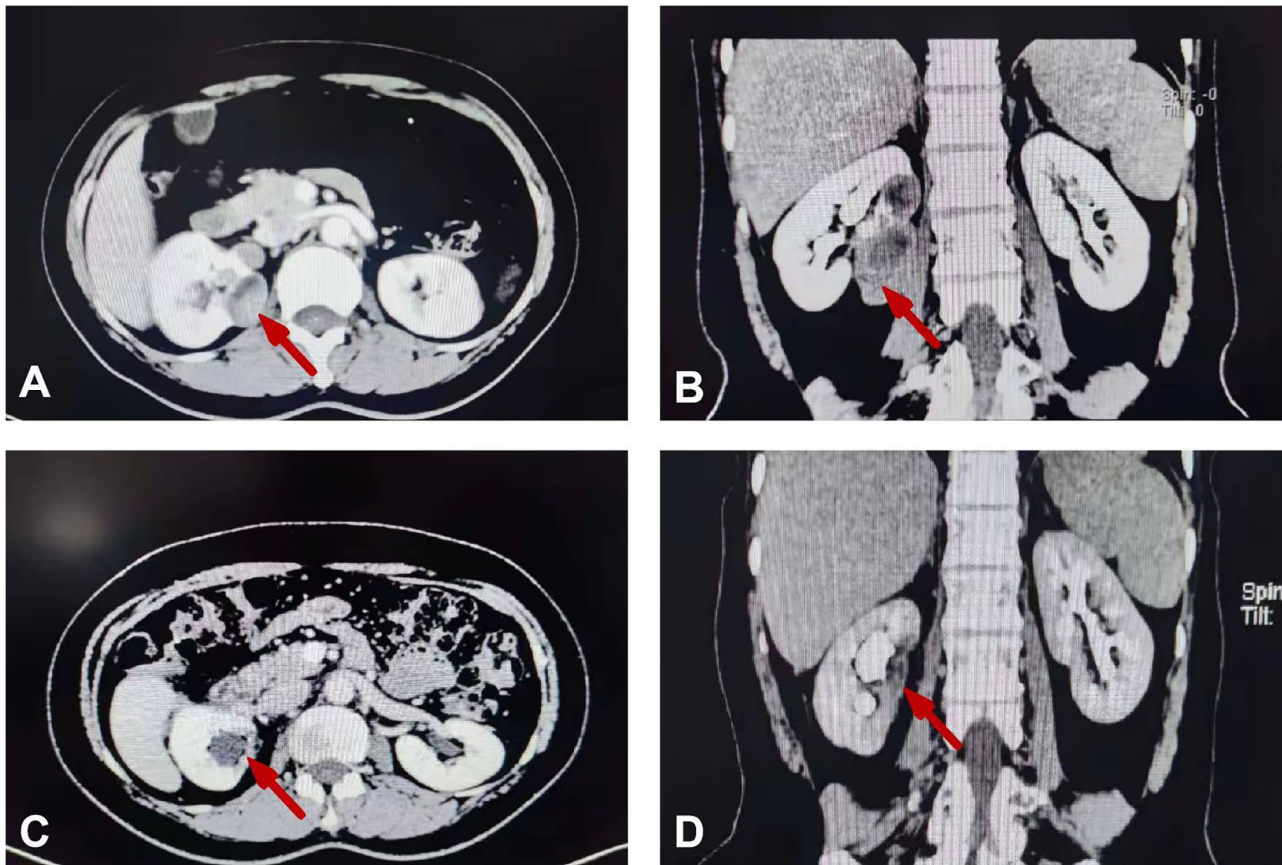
Results of abdominal computed tomography. (A) A well-circumscribed and slightly heterogeneous enhancing mass in the venous phase. The left kidney was normal. (B) The image demonstrated that the tumor was a 44x34x70-mm mass with a solid component, located in the right renal region and accompanied by sporadic fatty and calcified components. (C) At 1-year post-surgery, computed tomography indicated the absence of any residual tumor and mild hydronephrosis in the right kidney following partial nephrectomy. (D) The 3D reconstruction indicated that the tumor on the inside of the kidney was completely removed.
